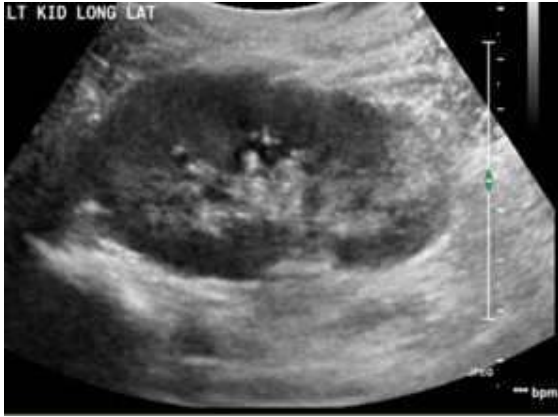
Ultrasound performed post-operative day 2.
